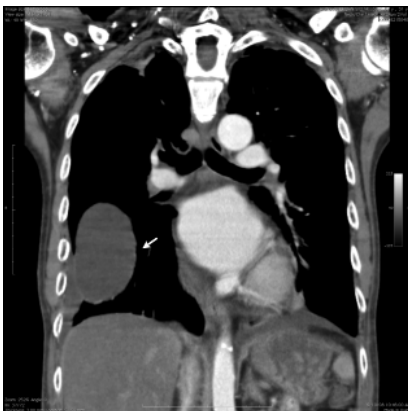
Coronal reconstructed image of the CT thorax.
